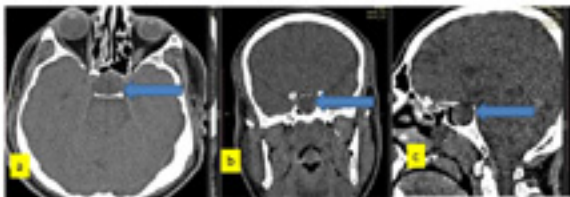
Preoperative CT scan patient number. a: axial, b: coronal, c: sagittal, non-enhanced CT scan of pituitary gland showing widened sella by well defined pituitary partly cystic macroadenoma
